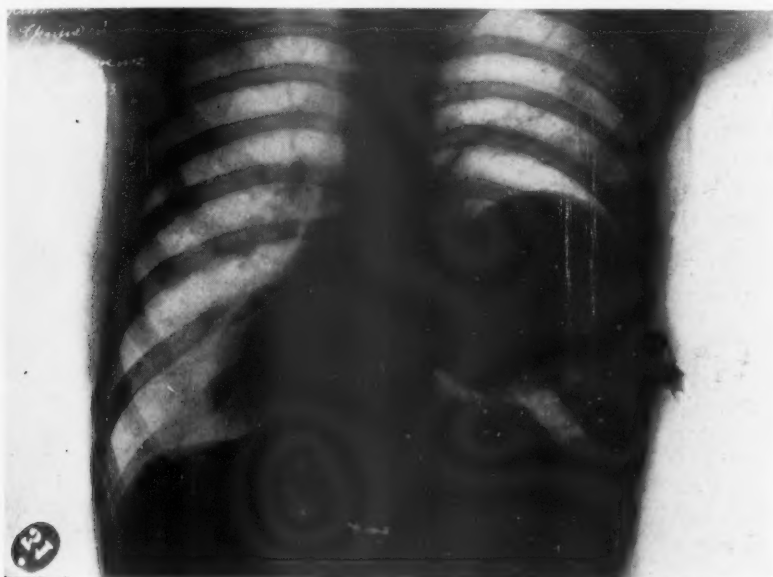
(Case XXVI.) Radiography after one of the two cysts had been operated upon.
